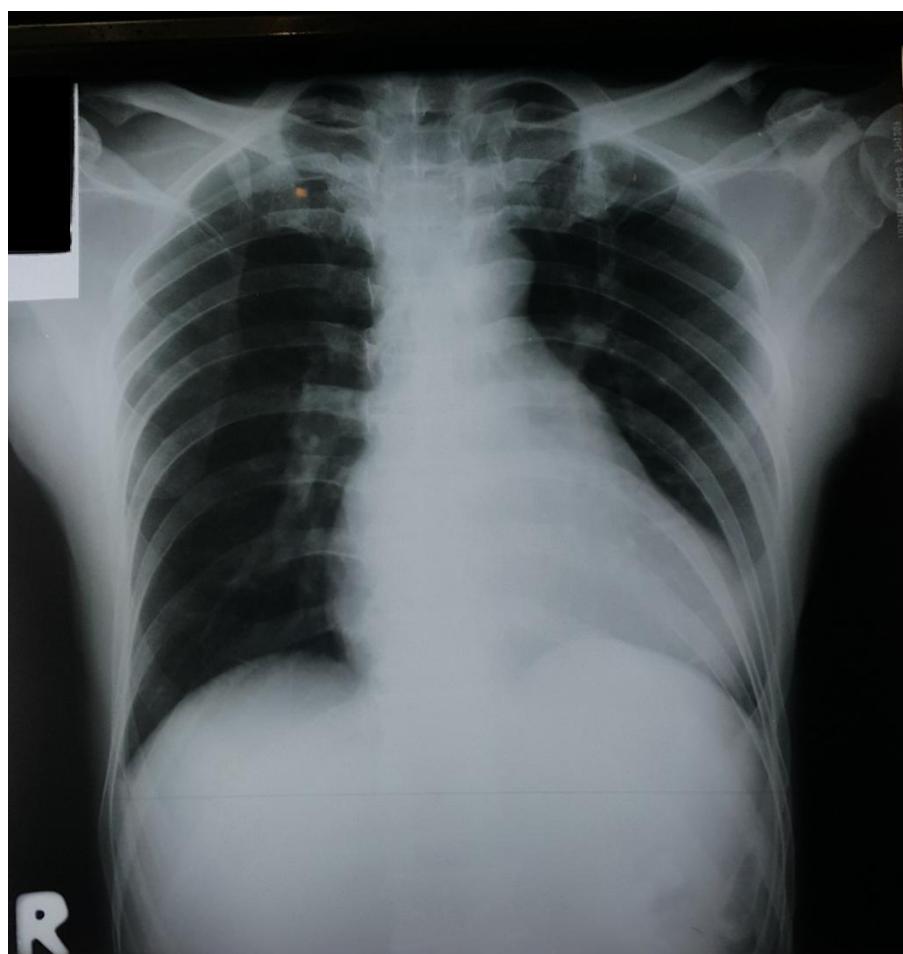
Patient's Chest X-Ray
